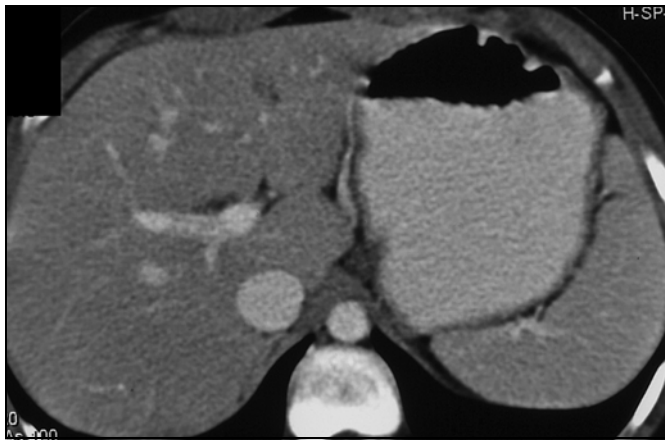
CT findings of diaphragmatic mesothelial cyst in 12-year-old girl.
